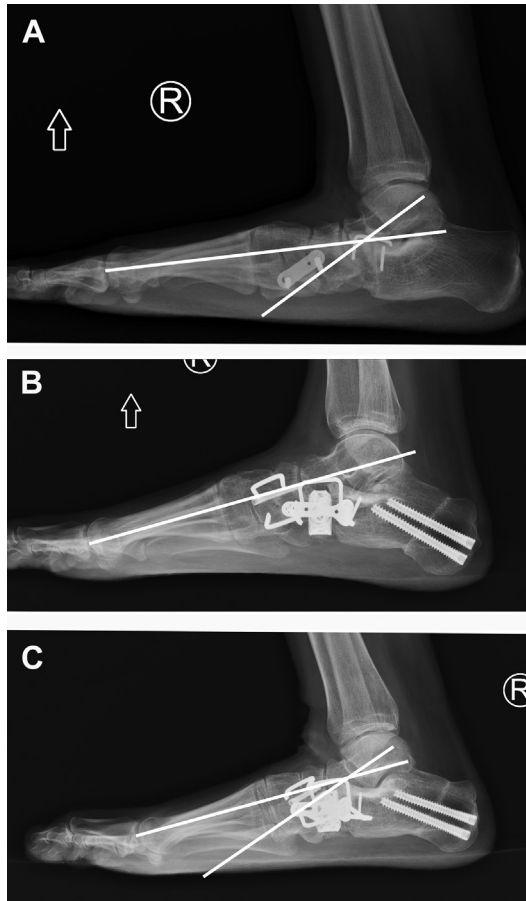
Lateral preoperative radiograph (A) of the same patient in Fig. 7 with clear collapse of the NC joint with a negative talar declination angle. At 3 months postoperative (B), complete restoration of sagittal balance was thought to be achieved. Radiographic collapse (C) is noted at 1 year with failure through the TN joint because there was union of the both the NC and CC lengthening arthrodesis based on computed tomography (CT) scan. On reexamination of the patient, the right foot was similar in appearance to the left asymptomatic foot, with complete patient satisfaction because she was able to return to all prior activities without pain. This case exemplifies that the goal of surgery is to restore patients to their preinjury/predeformity states, as opposed to theoretic radiographic parameters. Others may argue that this case is a prime example of the saying, “Better lucky than good.”
